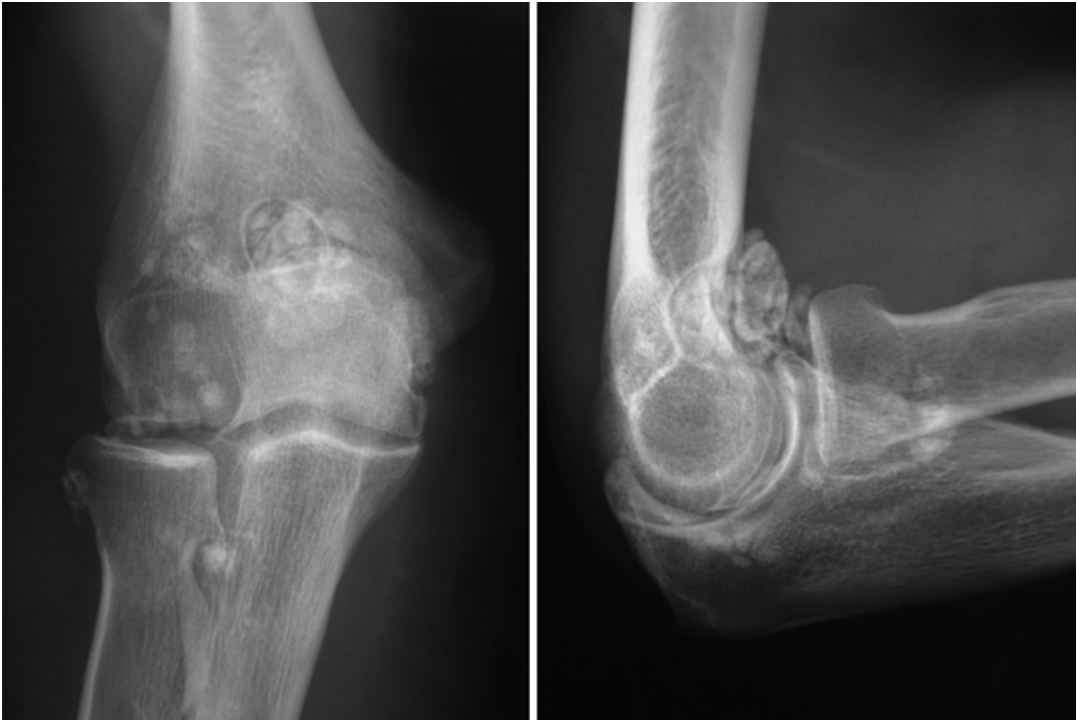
AP and lateral radiographs of the right (dominant) elbow of a 37-year-old manual worker with an 18-month history of pain and locking demonstrating characteristic appearances of primary synovial chondromatosis (PSC). The ‘loose bodies’ are mainly confined to the anterior compartment. Pressure erosion of the anterior humeral cortex can be seen in the lateral projection
